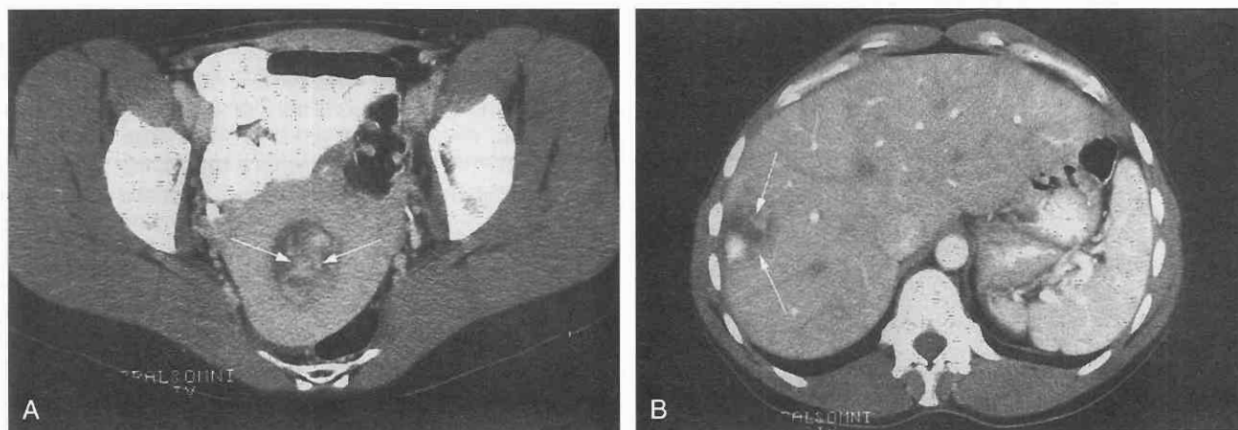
Gestational trophoblastic disease. A, CT scan through uterus shows a contrast-enhanced tumor (arrows) filling a dilated endometrial cavity and an intact myometrium. B, Dynamic CT scan through the liver shows a hypervascular metastasis (arrows).
